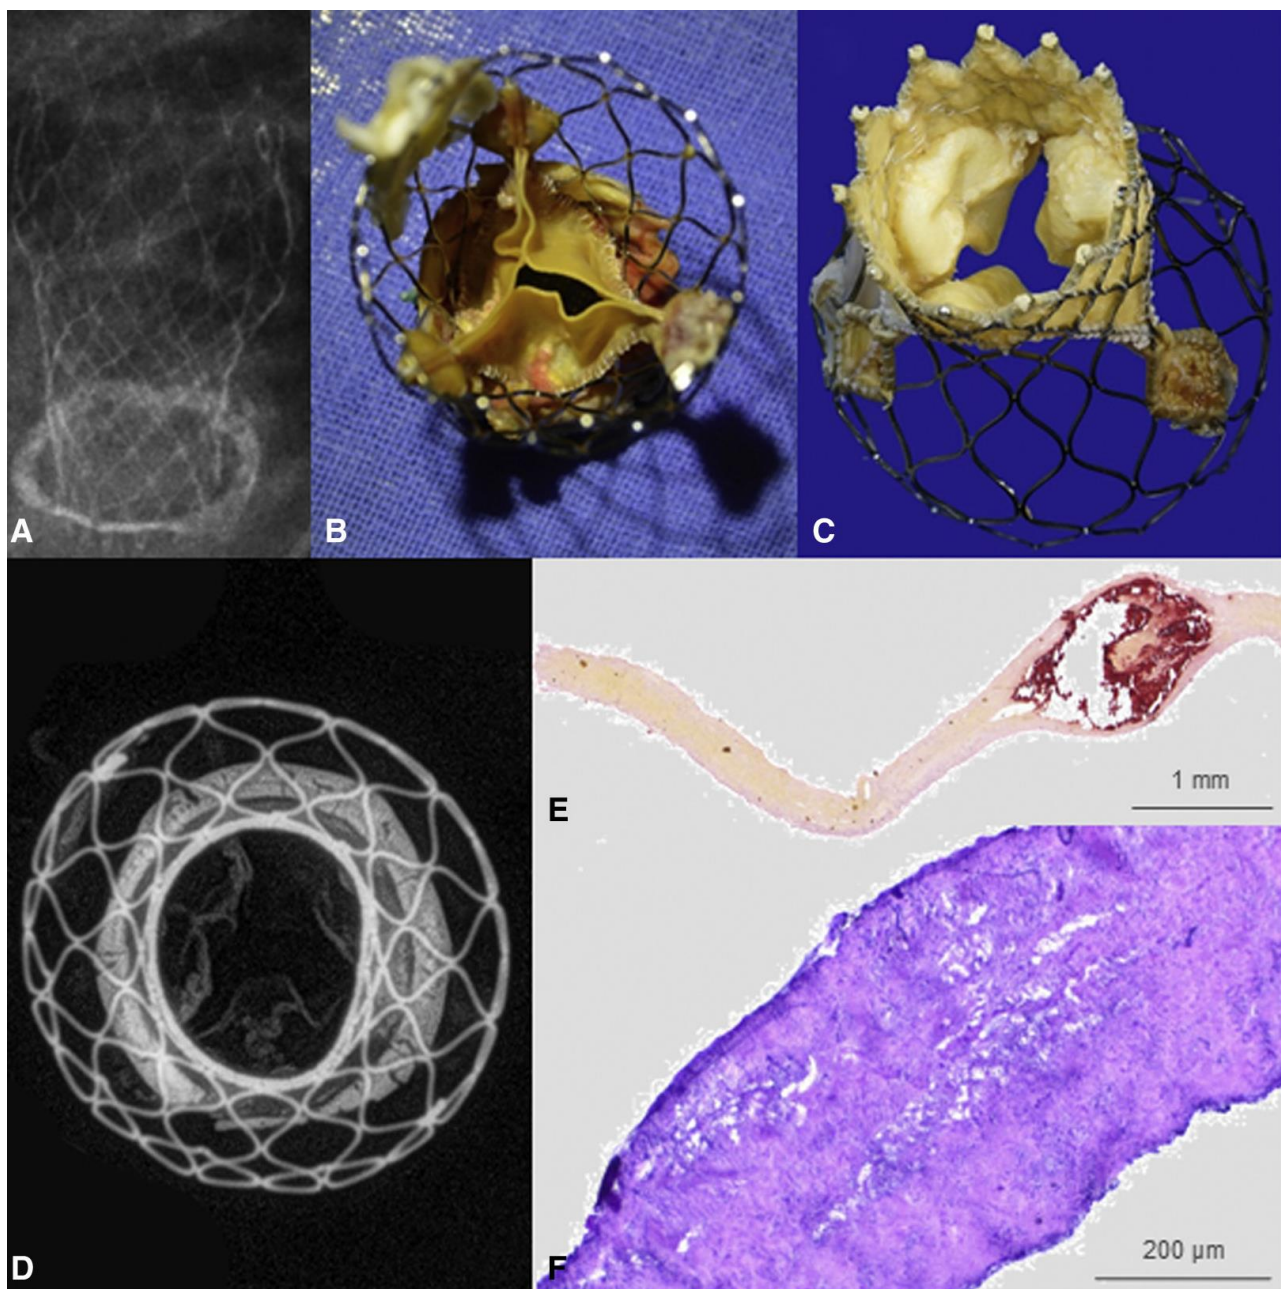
Early structural failure after transcatheter aortic valve-in-valve replacement. A, Section of patient's chest radiograph showing a 23-mm Core Valve transcatheter valve (Medtronic, Minneapolis, Minn) within a 21-mm Mitroflow conventional stented bioprosthesis (LivaNova PLC, London, United Kingdom). B, The explanted CoreValve-Mitroflow-corpus presenting pericardial folds and vegetating calcifications at the outflow aspects. C, Wrinkled pericardium and calcifications at the inflow aspect of the explanted CoreValve prosthesis. D, Radiographic examination demonstrates an ovalized, noncircular cross-sectional profile of the transcatheter valve within the stented bioprosthesis, as well as multiple calcifications at all leaflets of the CoreValve prosthesis.
